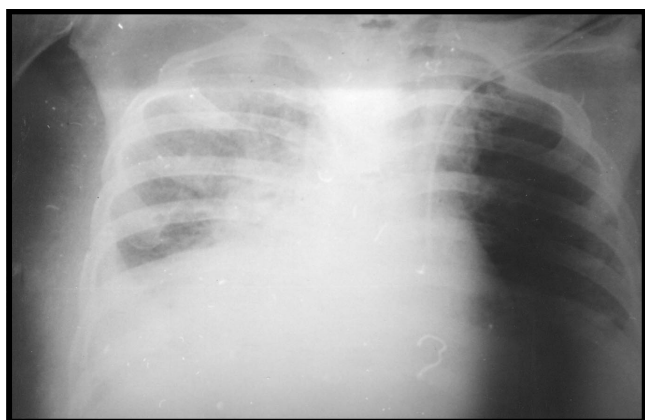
Chest x-ray showing a shifted trachea to the right due to a mass in the left side of the neck with gas at the site of left thyroid lobe.
